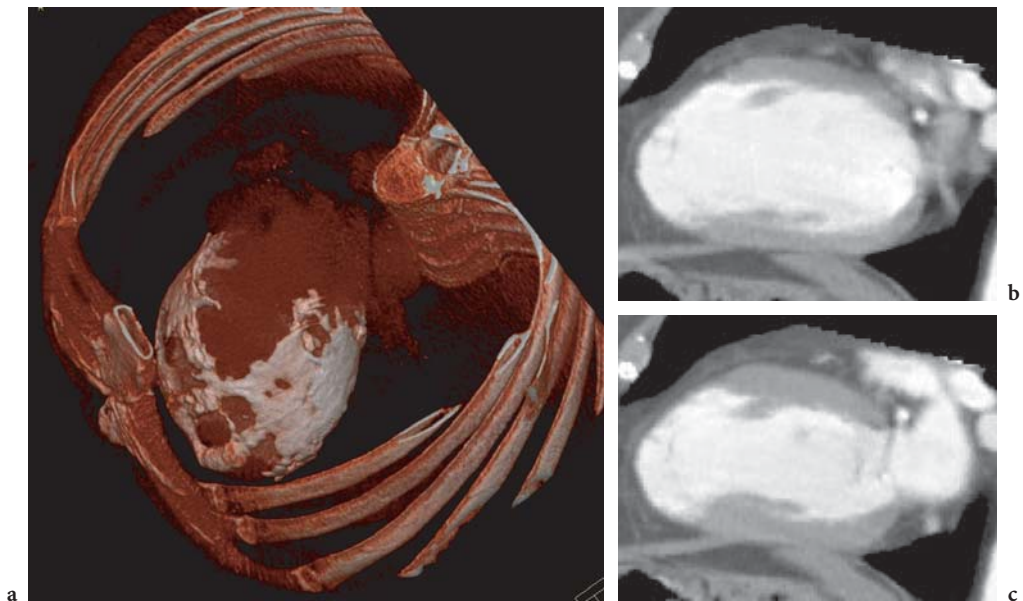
Patient with severe 3-vessel disease, pericarditis, and a functional defect was examined with 16-slice CT. a VRT reveals calcium deposits in the pericardium resulting from the pericarditis. Long-axis reconstruction in end-diastole (b) and end-systole (c) reveals the related reduced left ventricular function. (Case courtesy of Erlangen University, Germany)
